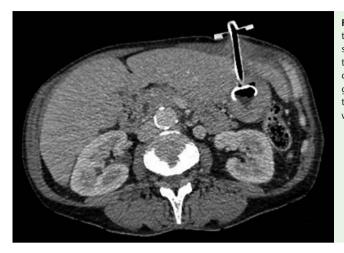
Computed tomography (CT) scan showing marked hepatomegaly with the percutaneous endoscopic gastrostomy (PEG) tube incorrectly placed within the liver.
